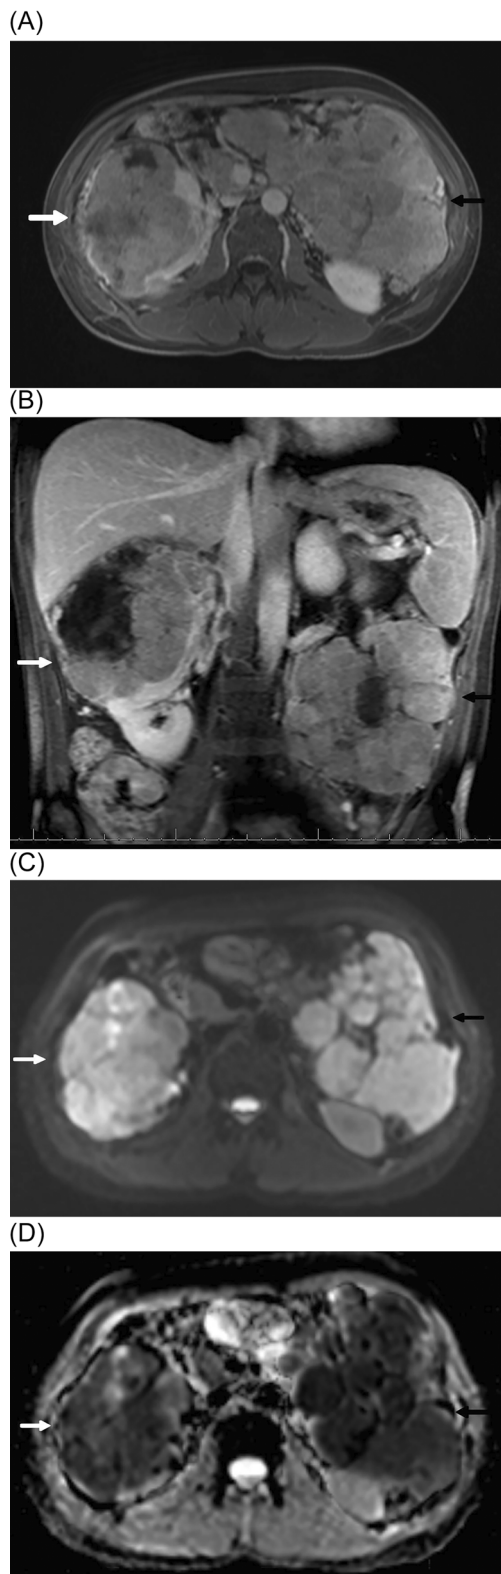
Post-contrast axial (A) and coronal (B) T1-weighted images demonstrate a complex enhancing mass in the upper pole of the right kidney (white arrow) and a lobulated mass in the left mesentery (black arrow). Diffusion-weighted imaging (DWI) (C) and the apparent diffusion coefficient (ADC) map (D) images demonstrate restricted diffusion in both the right renal mass (white arrow) and the mesenteric mass (black arrow).
